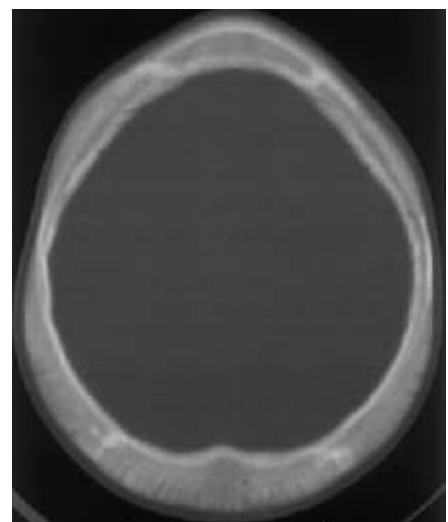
Axial CT scan of brain in bone window showing expansion of diploic space due to marrow expansion in skull.
